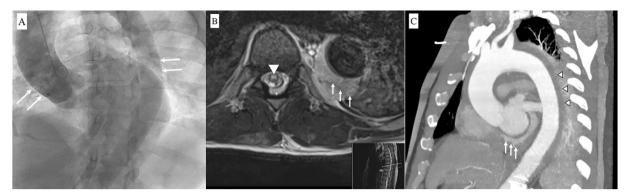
Anotography did not show any narrowing concerning for aortic dissection. Fig. B Whole spine magnetic resonance imaging showed increased T2 signal intensity and diffusion restriction predominantly involving the central gray matter of the spinal cord (white arrowhead). There was an abnormal enlargement of the descending aorta wall (white arrow). Fig. C Computed tomography angiogram demonstrated a small volume of pericardial effusion (white arrow) and intramural hematoma extending from ascending to the suprarenal aorta without evidence of great vessel occlusion, flap, extravasation of contrast, or hemothorax (white arrowhead).
